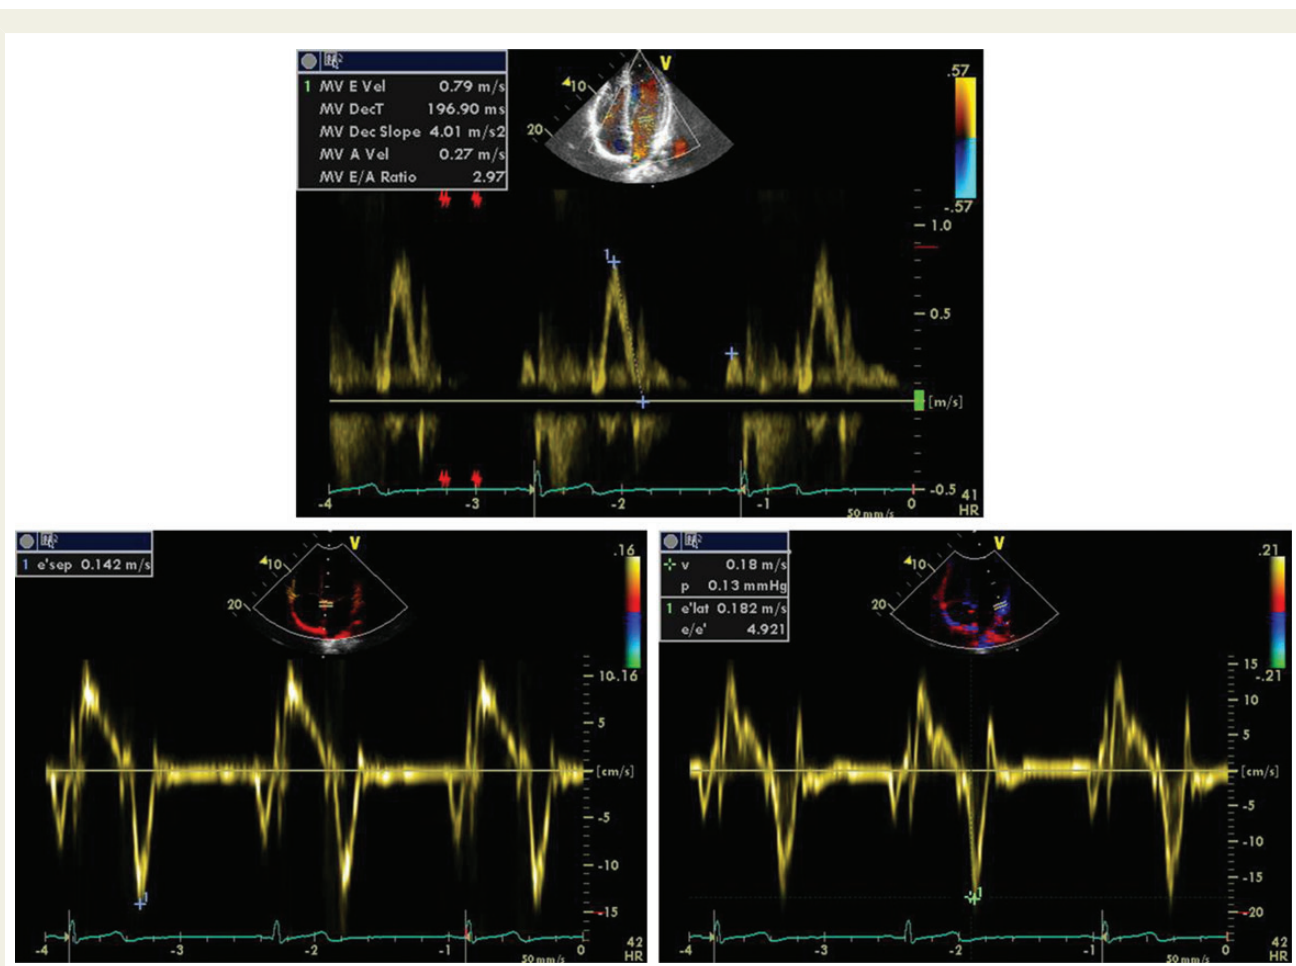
Supranormal LV diastolic function in a competitive runner. In the upper panel, standard Doppler-derived transmitral patterns shows an E/A ratio = 2.97. In the lower panel, pulsed tissue Doppler-derived e' velocity is very high at both septal (left) and lateral mitral annulus (right) and E/ e' ratio (= 4.9) is consistent with a normal diastolic function.
